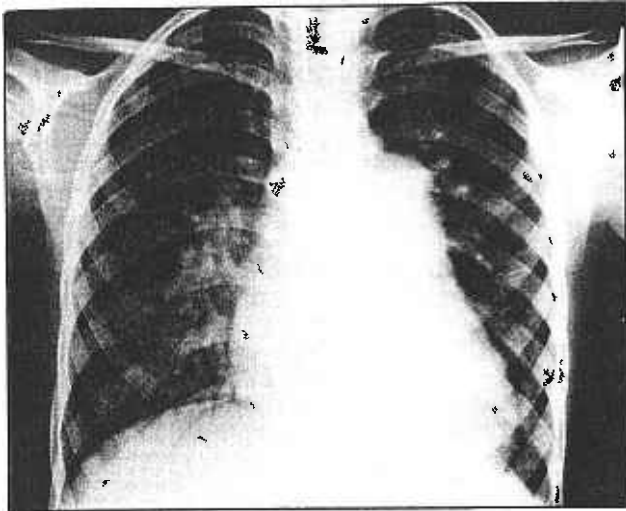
Chest roentgenogram showing cardiomegaly, prominent pulmonary conus with proximal pulmonary vascular plethora and peripheral vascular pruning (Eisenmenger's syndrome).
